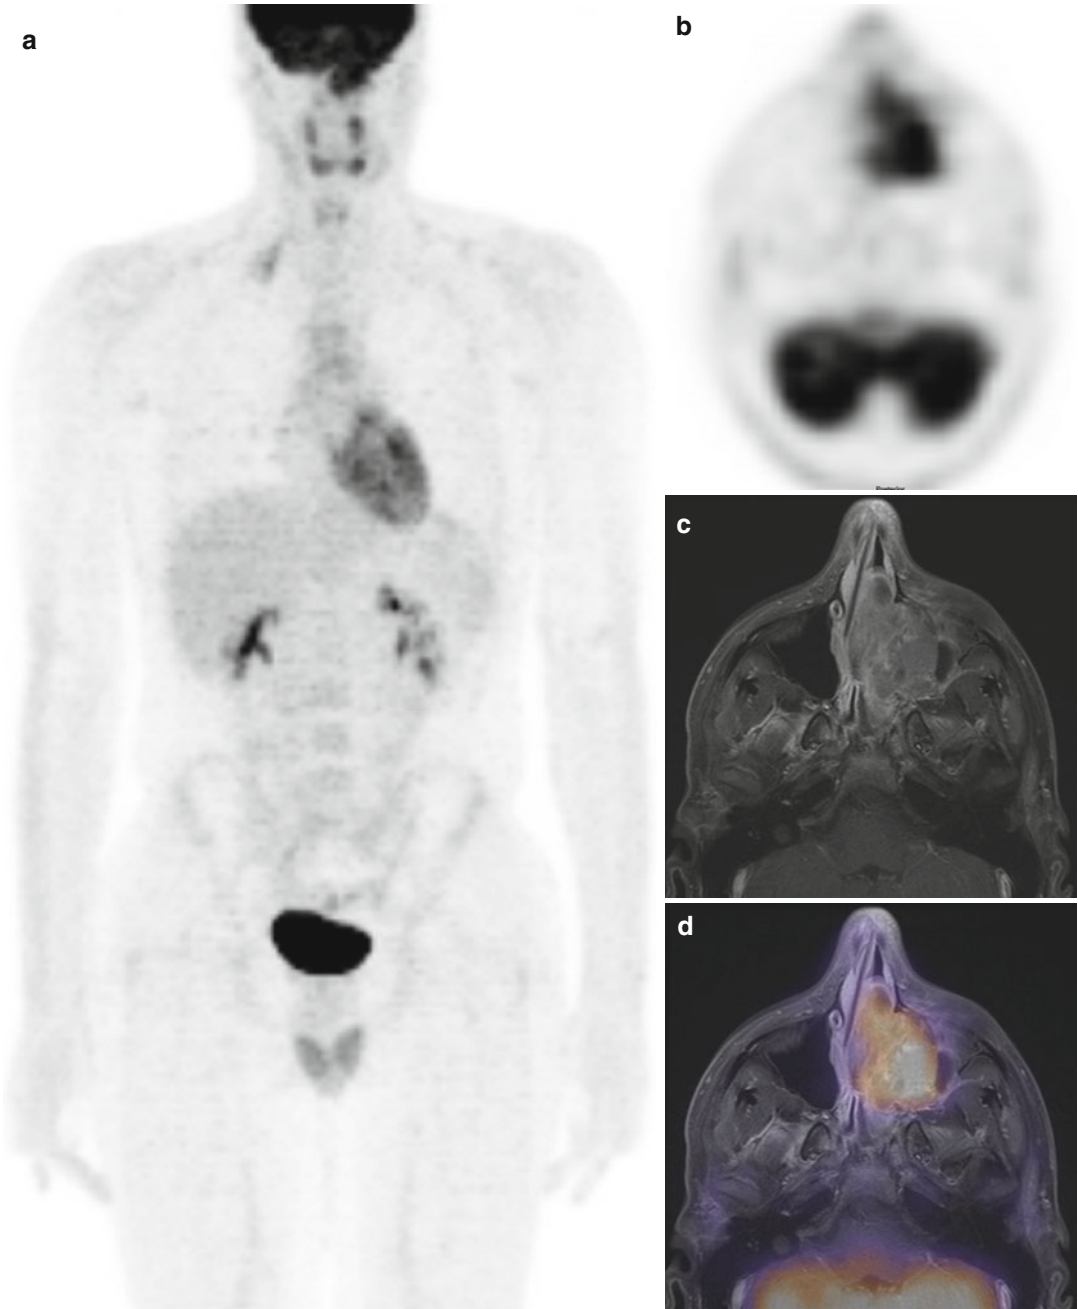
^{18}F -FDG PET and MRI of a sinonasal alveolar rhabdomyosarcoma in a 14-year-old boy. (a) The MIP of the ^{18}F -FDG PET shows a region of intense uptake at the base of the skull. No other sites of abnormal ^{18}F -FDG uptake are identified. (b) In the transaxial plane, the abnormal ^{18}F -FDG uptake appears to be in the expected location of the nasal cavity and left sinuses. (c) An axial
